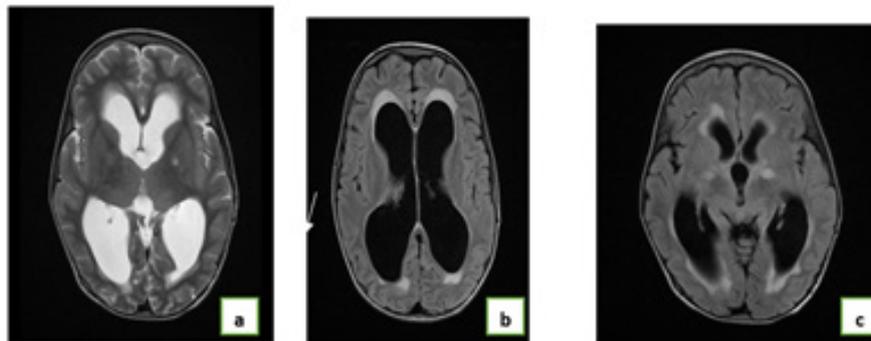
MRI of the axial cup T2(a)and FLAIR(b, c)showing tri-ventricular hydrocephalus ave-cresorption trans-ependymal) et FLAIR (ass coupled withée s X2 hypersignal signal abnor-malities and FLAIR of internal bilaté-perminating bilae on rale the left side in relation to "OBNI".
